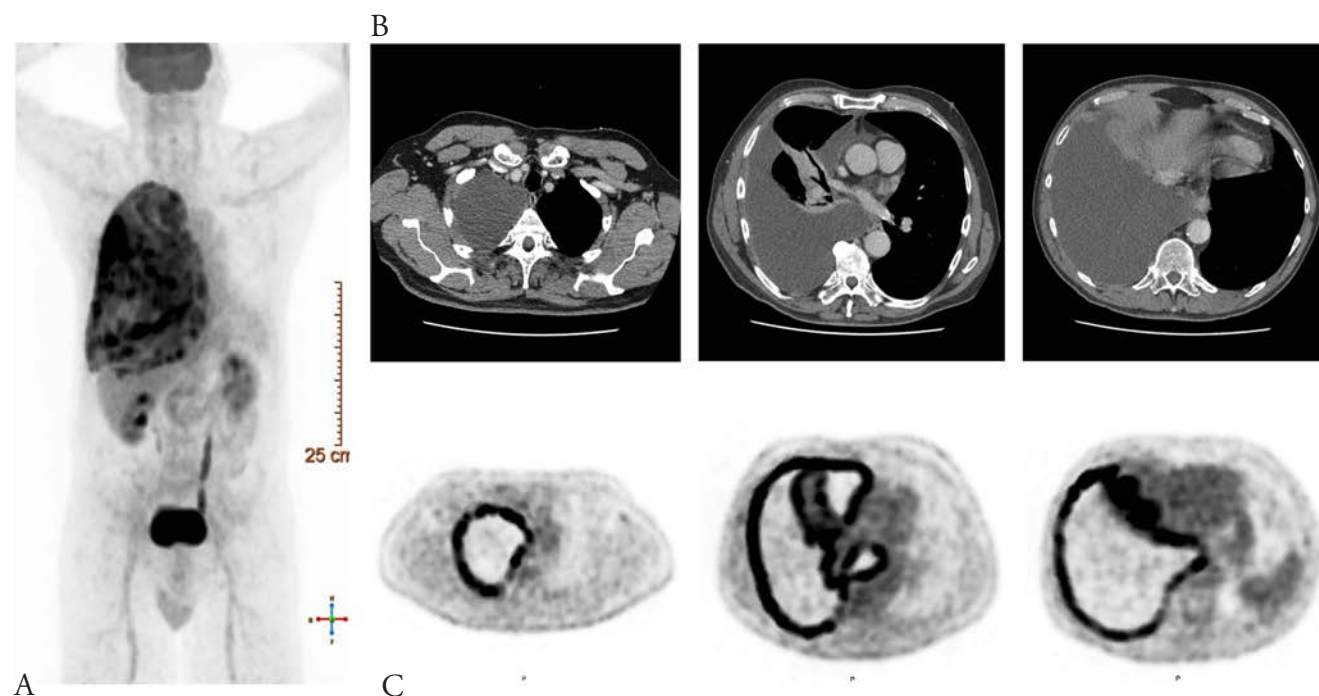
Imaging of the chest. A) Positron emission tomography-computed tomography (PET-CT) whole body; B) non-contrast CT chest; C) PET CT chest.
